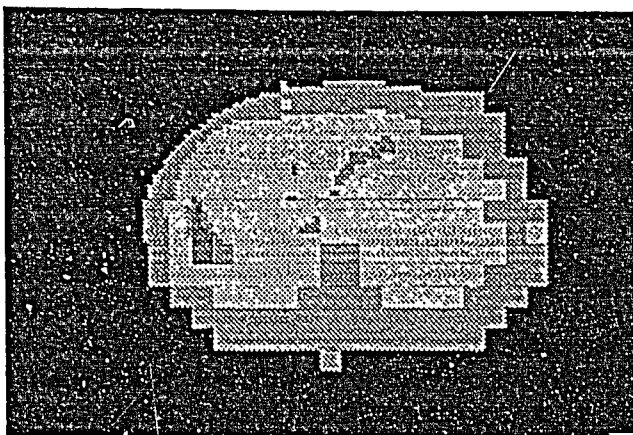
Slice of the Monte Carlo model equivalent to the CT scan of figure 1. Adipose, lung and other soft tissues are modelled, in addition to more accurate geometric representation in the area of the liver - the target of the epithermal neutron beam.
